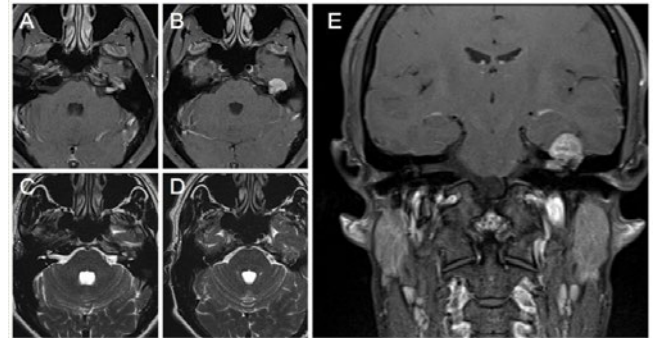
Pre-operative MRI shows a mass hypo to iso-intense on T1-weighted and iso to hyper-intense on T2-weighted images with enhancement after administration of paramagnetic contrast.
